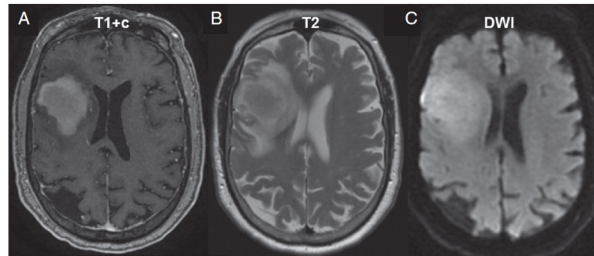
PCNSL imaging pattern on MRI. (A) MRI T1 sequence with gadolinium contrast (T1+c) reveals homogeneously enhancing deep lesions. (B) Lesions are iso- to hyperintense on T2 imaging with a relatively small amount of edema. (C) Diffusion-weighted imaging (DWI) demonstrates restricted diffusion in the tumor.
